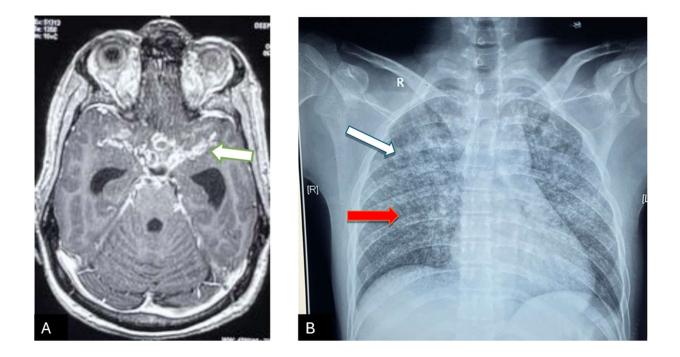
Chest radiograph in TB meningitis (A): Contrast Enhanced-MRI Brain (T1W axial section) showing extensive enhancing exudates with numerous conglomerated ring-enhancing lesions (white arrow) within basal subarachnoid cisterns and bilateral sylvian fissures with dilatation of temporal horns of lateral ventricles, suggestive of hydrocephalus. CSF CBNAAT was positive for TB. (B): Chest radiograph-supine (AP view) showed infiltrative lesions (white arrow) in right upper zone with miliary mottling (red arrow) in rest of the lung fields, suggestive of Pulmonary TB.
